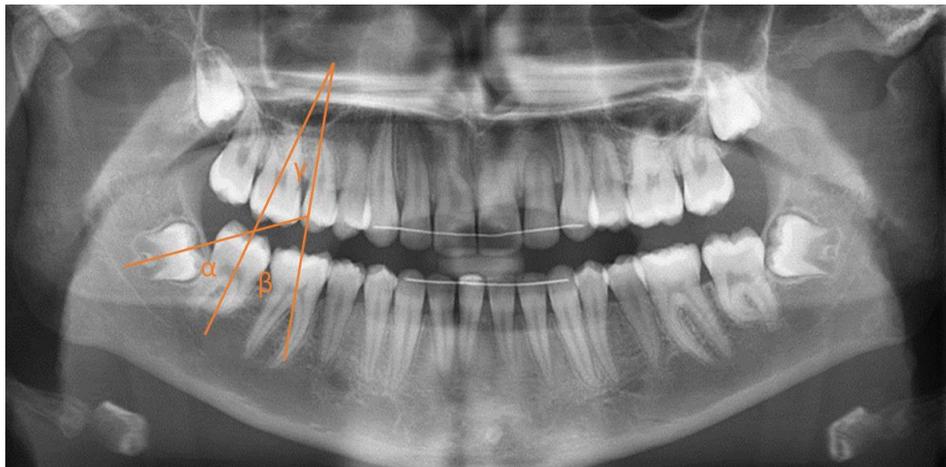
Measurement of the mandibular molar angulations on panoramic radiographs: α represents the third to second molar angulation, β the third to first molar angulation, and γ the second to first molar angulation.
